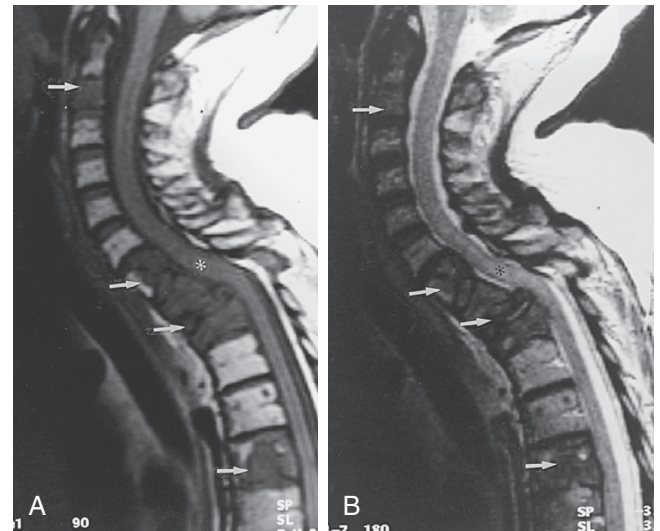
■ Metastatic disease. Sagittal T1-weighted (A) and T2-weighted (B) magnetic resonance imaging scans of spine show metastatic lesions (*arrows*) as low intensity on T1-weighted image, replacing normal bright marrow. High signal within uninvolved vertebral bodies represents postradiation changes. Hypointense lesions on T2-weighted image (in contrast to more typical hyperintensity) reflect posttreatment appearance. Multiple compression fractures are identified within upper thoracic spine, with collapse, retropulsed fragments, and cord compression. Edematous changes within cord secondary to compression (*asterisk*) are also identified.
